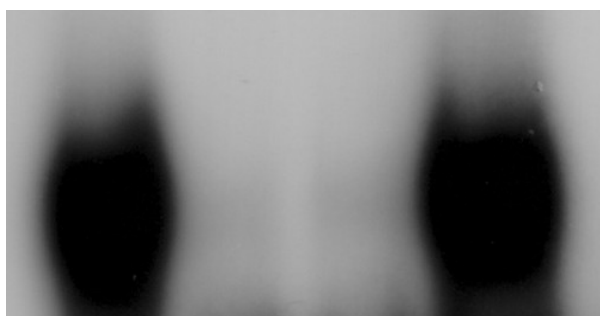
Representative radiographs of NF-kappaB competition experiments in PBMCs of patients with acute pancreatitis and healthy controls. Lane 1: positive control; lane 2: 1x specific inhibitor; lane 3: 10x specific inhibitor; lane 4 non-specific inhibitor. The middle two lanes are blank, as should be expected.
